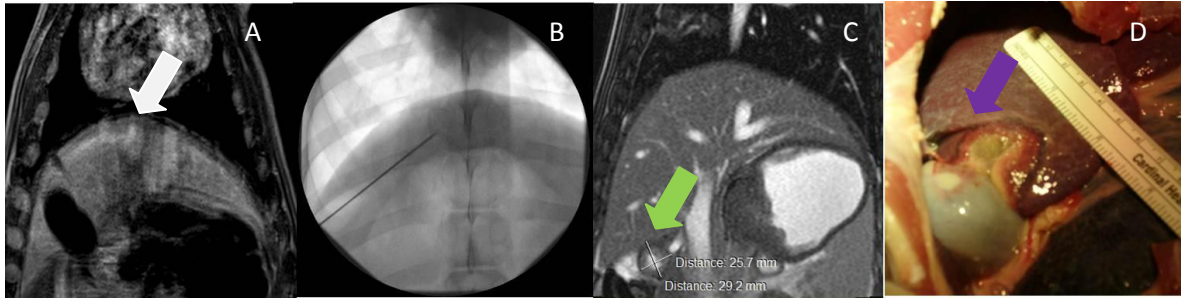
A: MR image (VIBE) used for treatment planning in the liver (white arrow) B: Needle placement in the liver (Fluoroscopy image); C: Post-ablation MRI (True FISP), showing the ablated area in the liver (green arrow); D: Necropsy image showing the ablated area in the liver (purple arrow).
